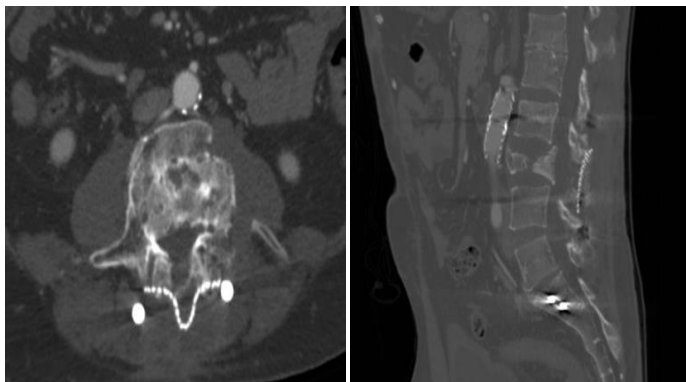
(A-B) Case 2. CT images of L4 burst fracture and left foraminal stenosis
